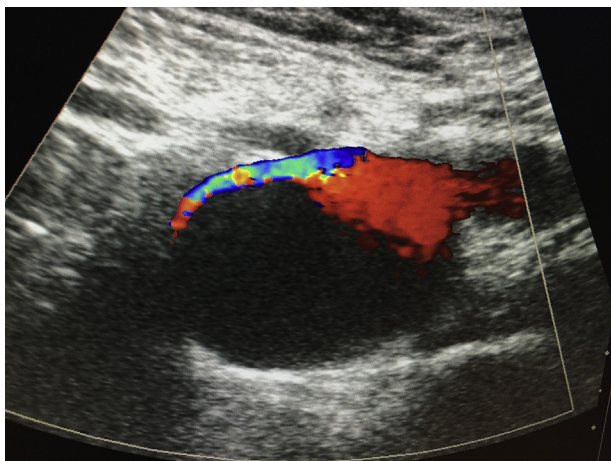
Preoperative ultrasound examination showing considerable stenosis of the external iliac vein (EIV), determined by the anechoic mass.
